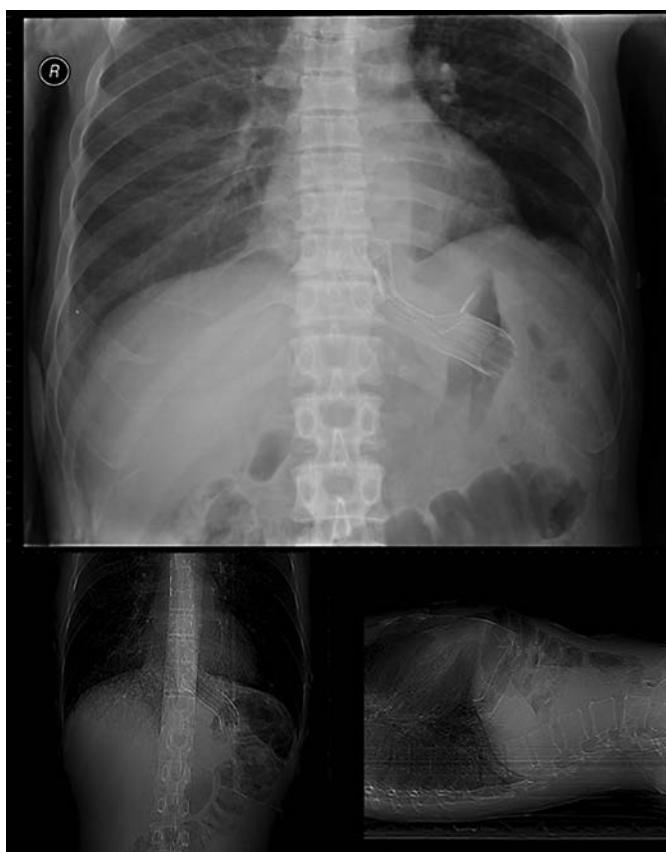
Radiologic and CT scout appearance of the Ultraflex® stent placement across the gastroesophageal junction. Higher flexibility allows better conformability in anatomically challenging areas like GI angulations, reducing the risk of pressure necrosis and migration.
